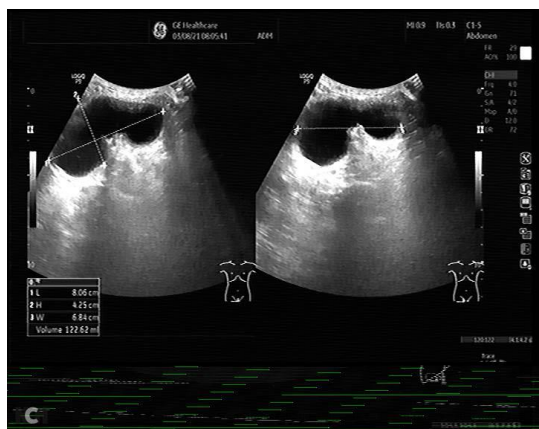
Ultrasound of the right groin
